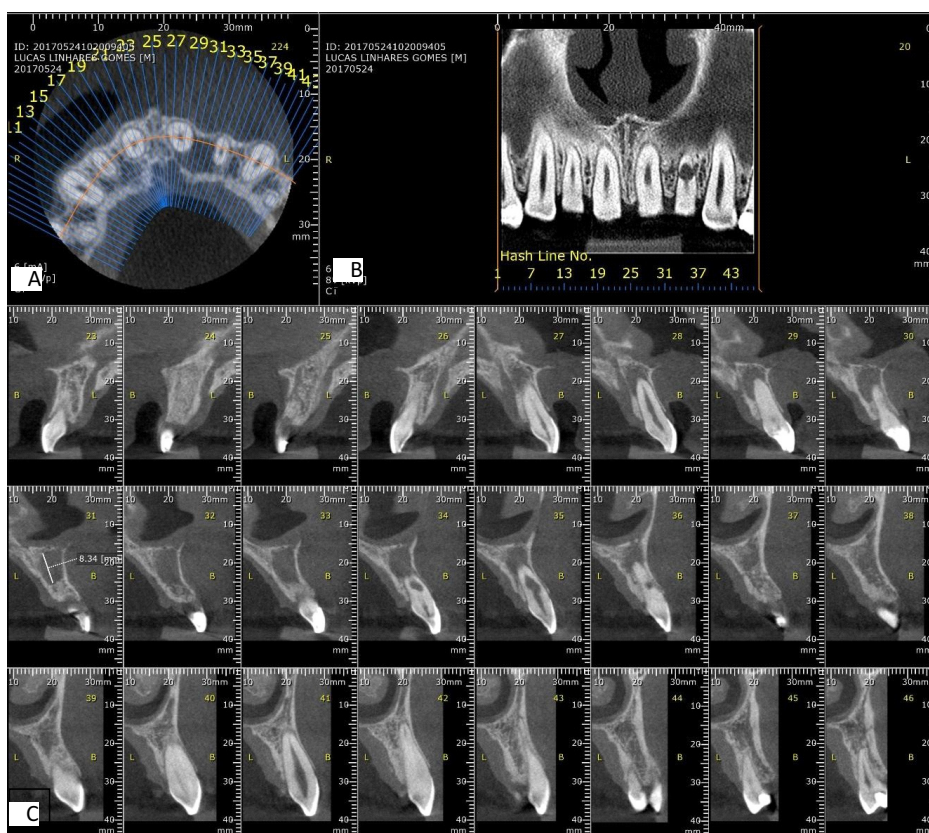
Cone Beam Computed Tomography for diagnosis of the requested region. A: Cross-sectional image. B: Coronal image. C: Sagittal image.
